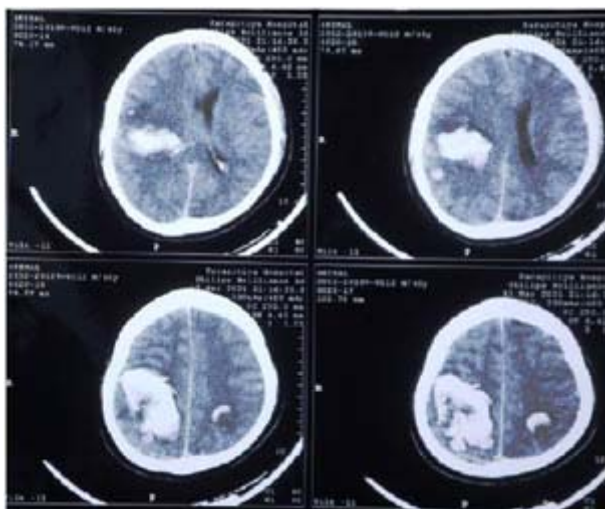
CT images and brain shows intra-cerebral haemorrhages and sagittal sinus thrombosis (white arrow)
